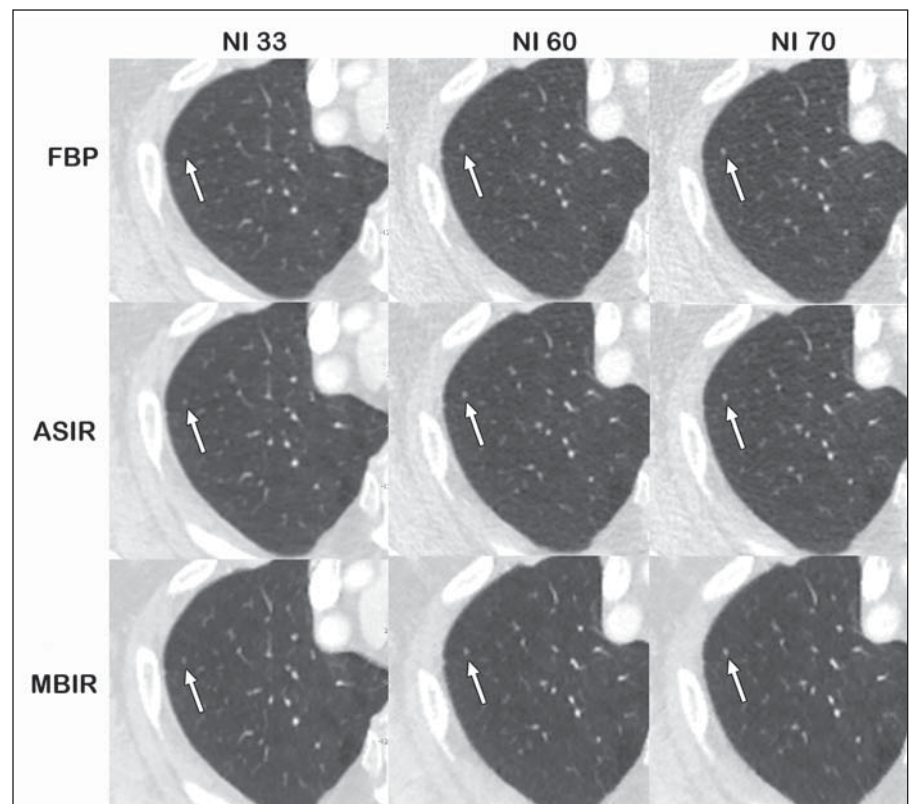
65-year-old man with known diagnosis of cholangiocarcinoma. Transverse chest CT images show small lung nodule reconstructed with different algorithms as shown. Note that even submillimeter lung nodule as in this case is well seen across all reconstruction algorithms because of inherent high contrast of air to soft tissue nodule. ASIR = adaptive statistical iterative reconstruction, FBP = filtered back projection, MBIR = model-based iterative reconstruction, NI = noise index.
